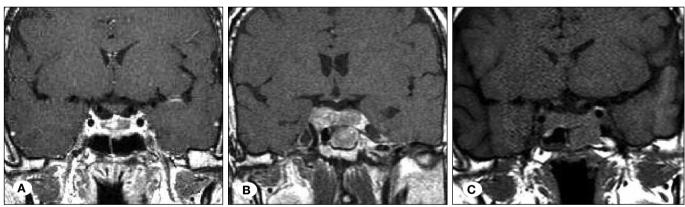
T1-weighted MRI (coronal view) shows a sellar and suprasellar mass with a hyperintense hemorrhage (A-B preoperative images, C after operation).
